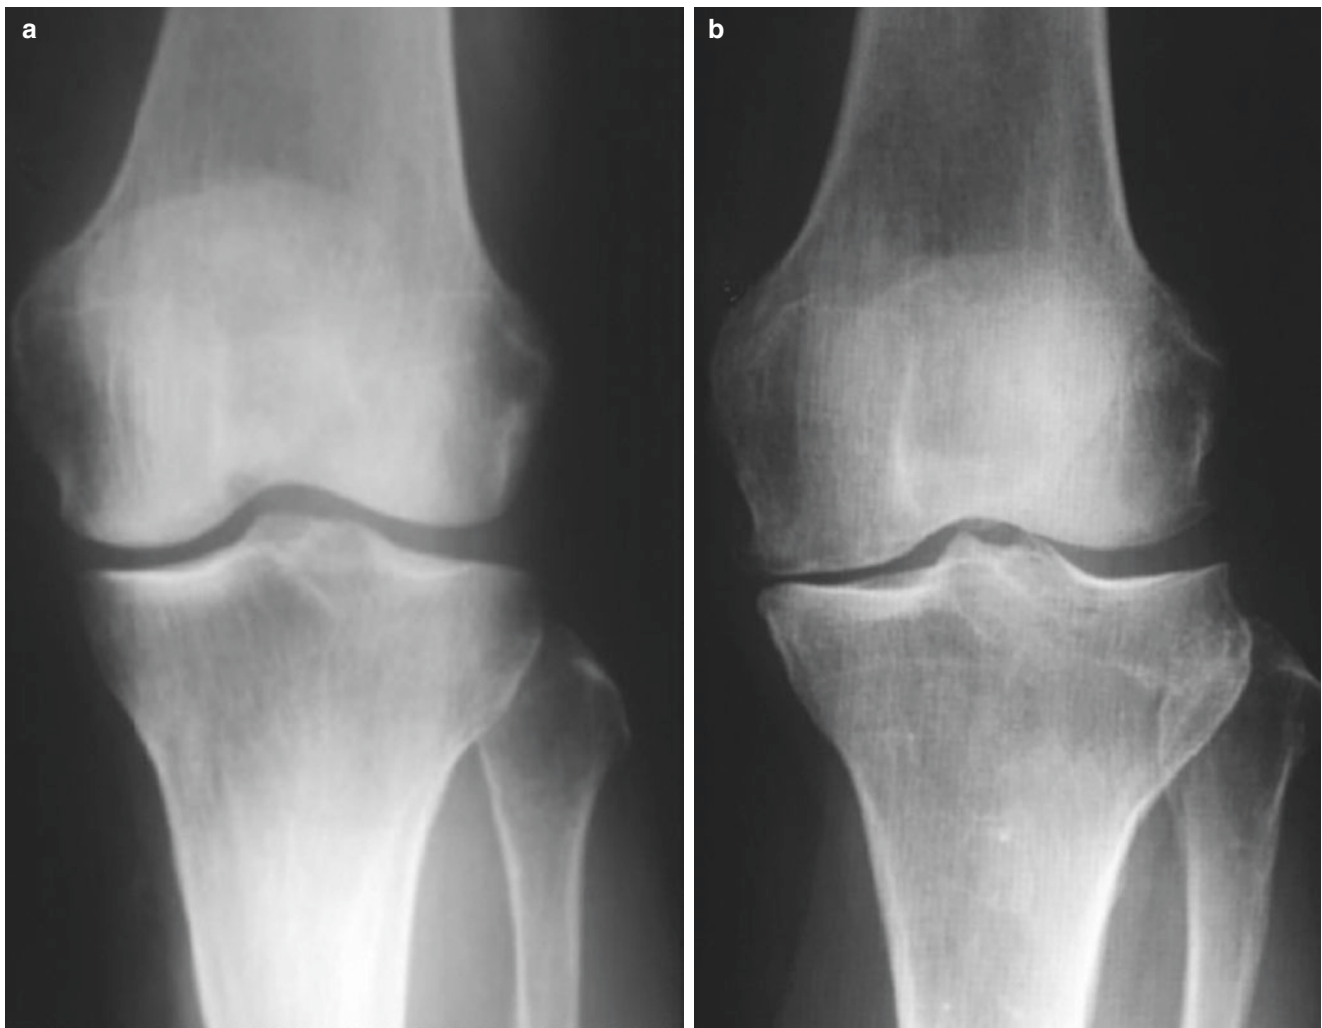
AP plain X-rays of Kellgren–Lawrence grade 1 (a) and grade 2 (b). (Reproduced from Akira Horikawa et al. [62])
